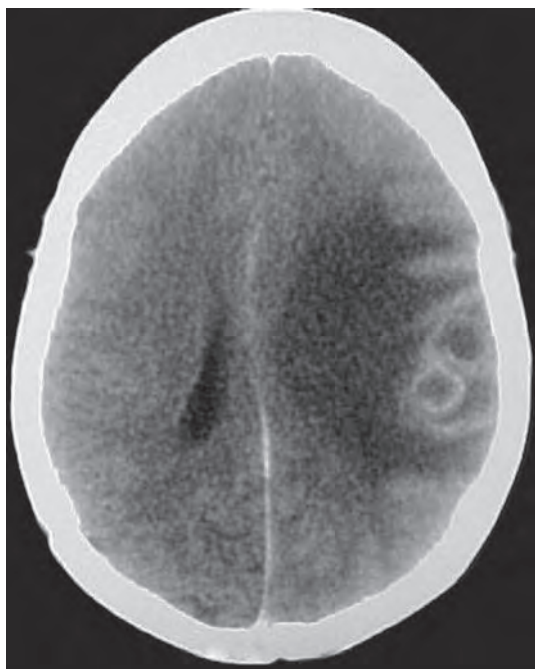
CT scan showing right parietal tuberculoma with surrounding oedema and mass effect
